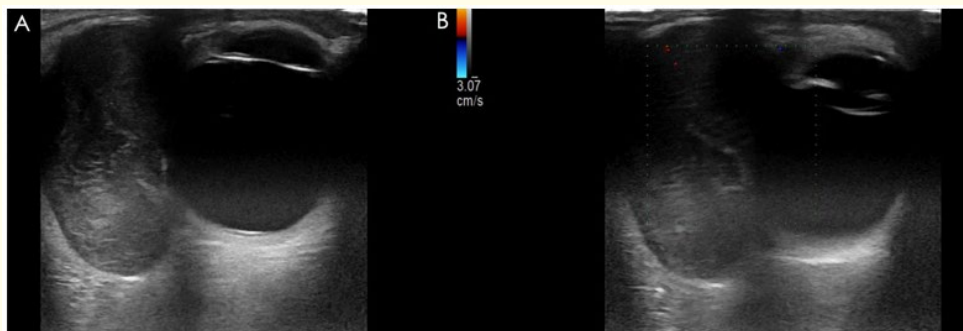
B-mode and Doppler ultrasound scan of the left palpebral swelling, revealing a well-defined oval tissue-like mass extending deep into the orbit (A) Notably, the mass is vascularized, as demonstrated on color Doppler imaging (B).
